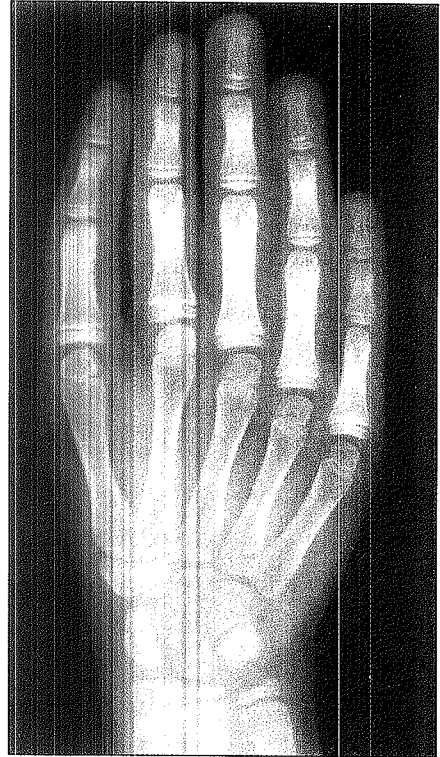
X-ray of a hand of a child with opposable triphalangeal thumb. Thenar muscles are well developed and there is no opposition impairment.*
